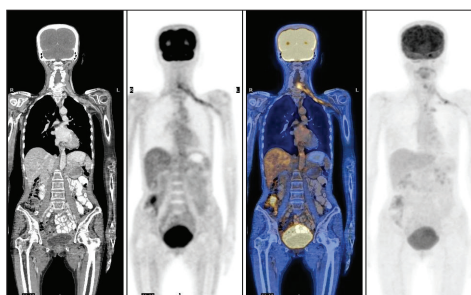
Maximum intensity projection (MIP) and coronal ¹⁸F-FDG PET-CT images show linear extension of tracer activity from superomedial aspect (supra/infraclavicular) to lateral aspect of the left axilla.
